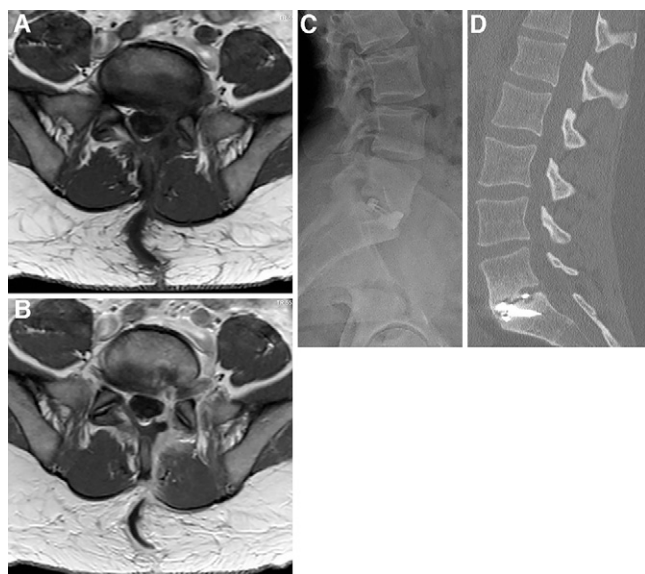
MRI demonstrating clinical course of patient in case 3, a 37-year-old male with epidural fibrosis undergoing anterior lumbosacral interbody fusion. Axial T1 (A) and T1-weighted (B) images demonstrate presence of epidural fibrosis around the lateral recesses, greater on the left, with tracking along the exiting nerve root on the right. C: Lateral standing radiograph demonstrates interbody cage at L5–S1. D: Sagittal computed tomography at 1-year follow-up demonstrating stable construct, stable spinal alignment, no hardware failure, and evidence of arthrodesis.
